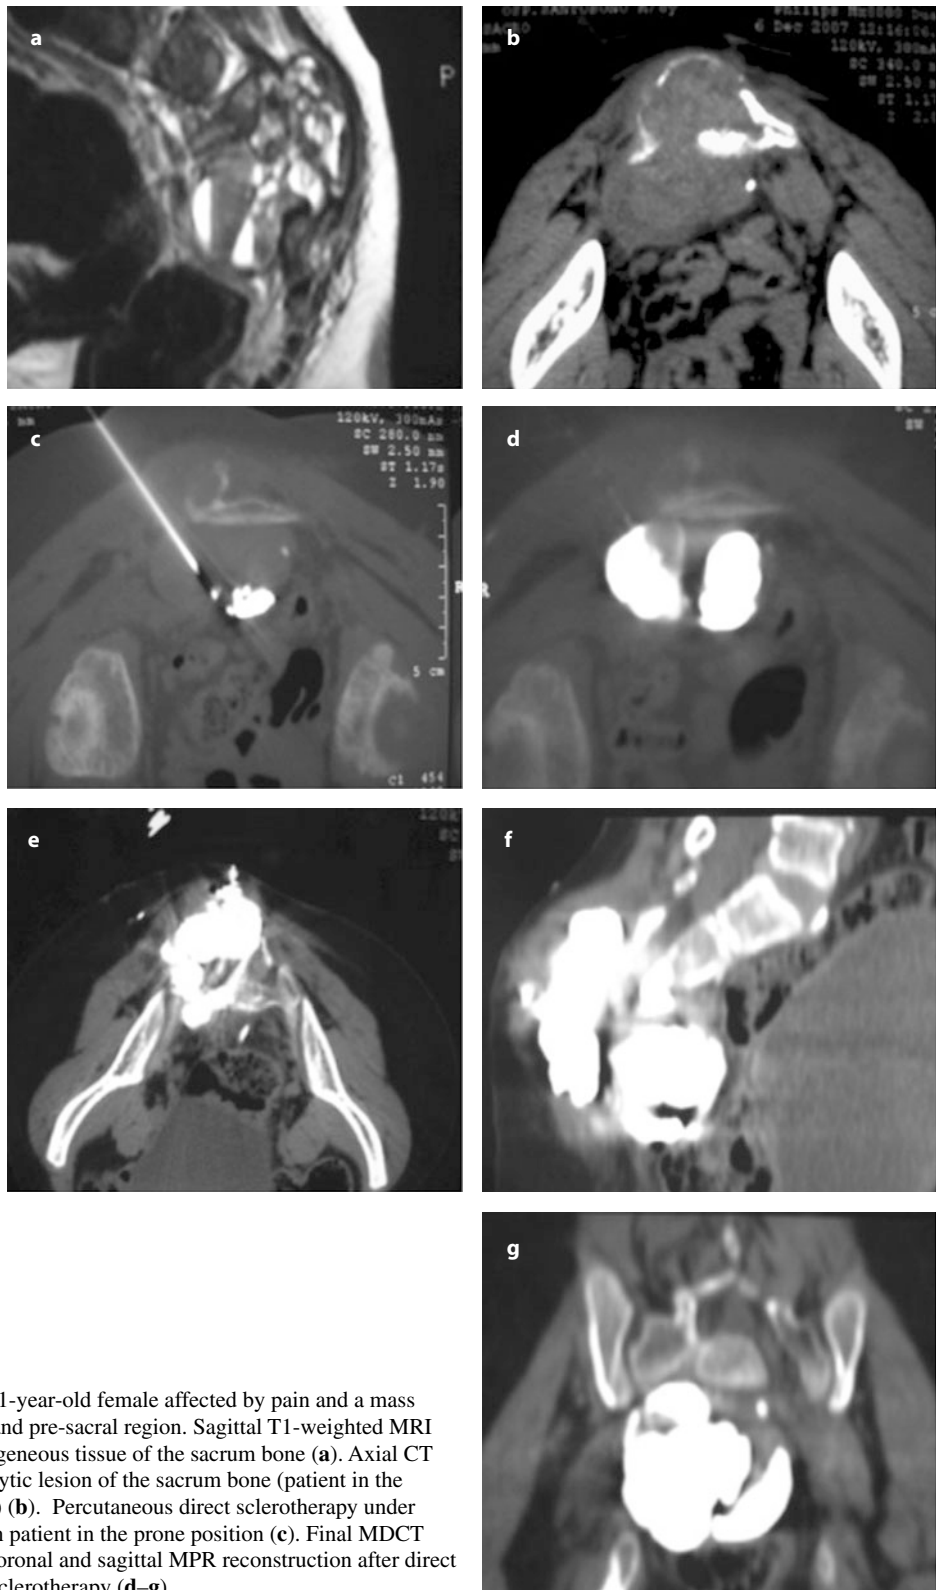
A 11-year-old female affected by pain and a mass in the lumbar and pre-sacral region. Sagittal T1-weighted MRI shows inhomogeneous tissue of the sacrum bone (a). Axial CT shows a large lytic lesion of the sacrum (patient in the prone position) (b). Percutaneous direct sclerotherapy under CT guidance in patient in the prone position (c). Final MDCT control with coronal and sagittal MPR reconstruction after direct percutaneous sclerotherapy (d–g)
